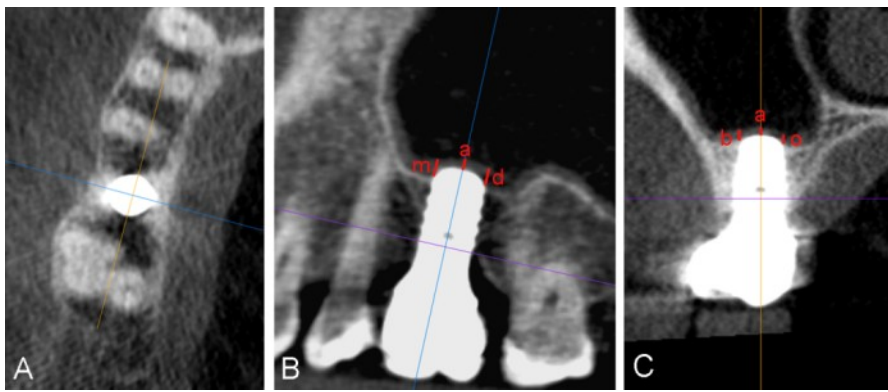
Cone-beam computed tomography image. Patient #5, site 16. Although the Schneiderian membrane was perforated at the time of surgery, the 10-year CBCT image didn't show membrane thickening. The membrane covered completely the implant dome.
